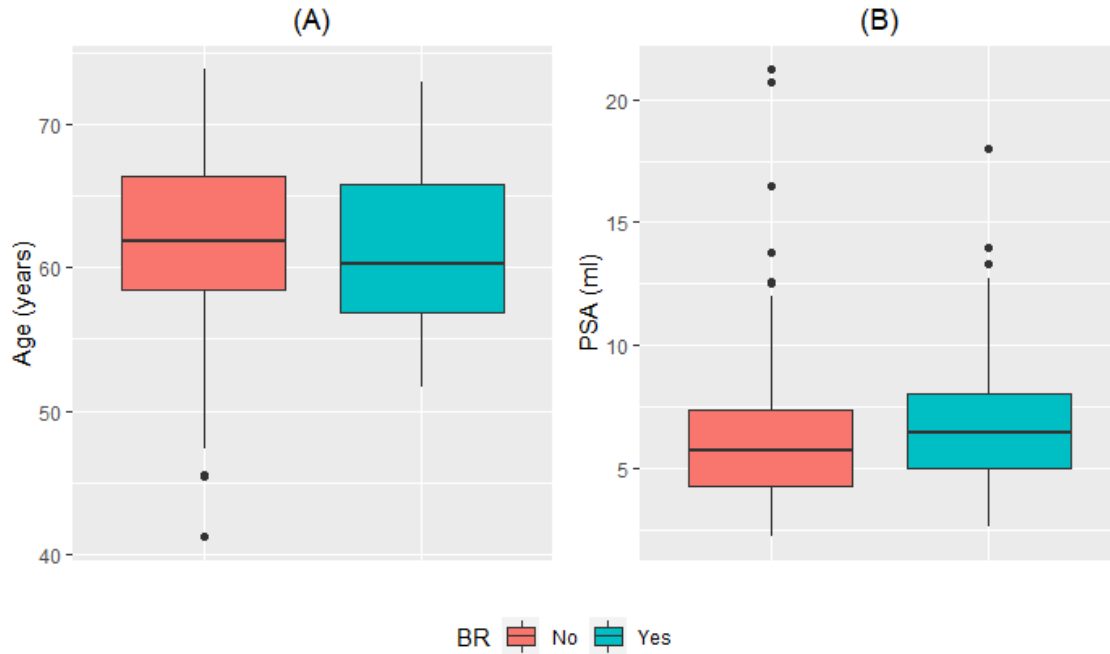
Box-plots of patients with or without biochemical recurrence by: (A) Age at MRI in years and (B) PSA at MRI in ng/ml
